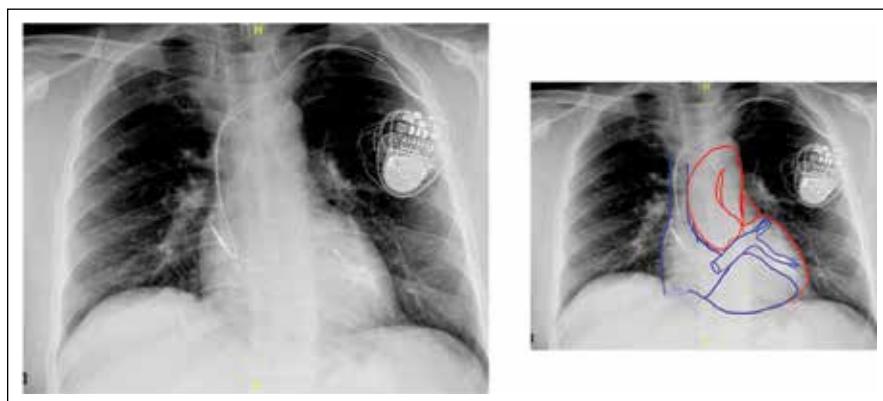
Frontal chest radiograph of a patient who underwent CRT-P insertion showing various lead positions (RA, RV, LV). Annotated image of the same.
